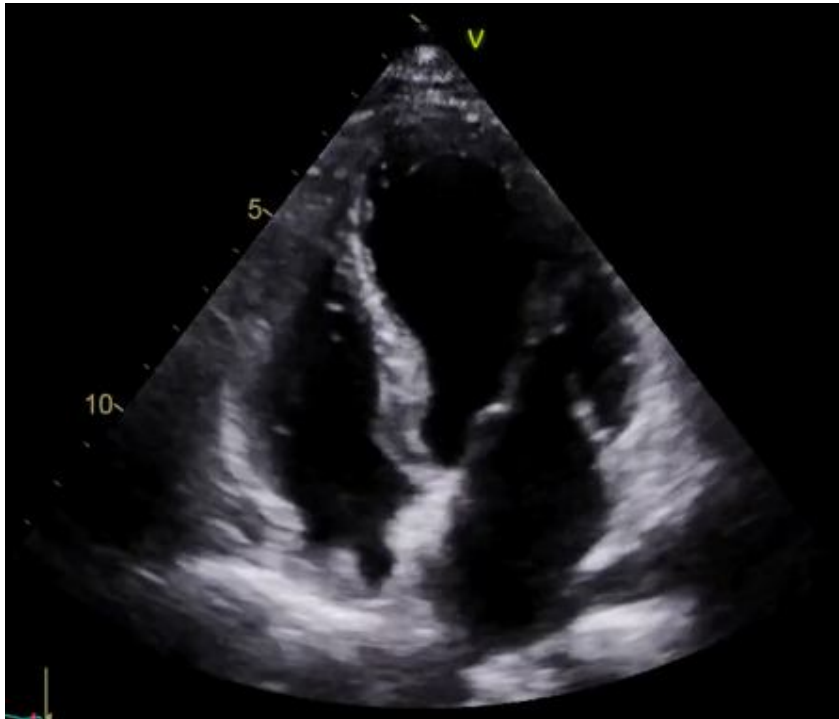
Transthoracic echocardiography demonstrating characteristic apical ballooning of the left ventricle.
